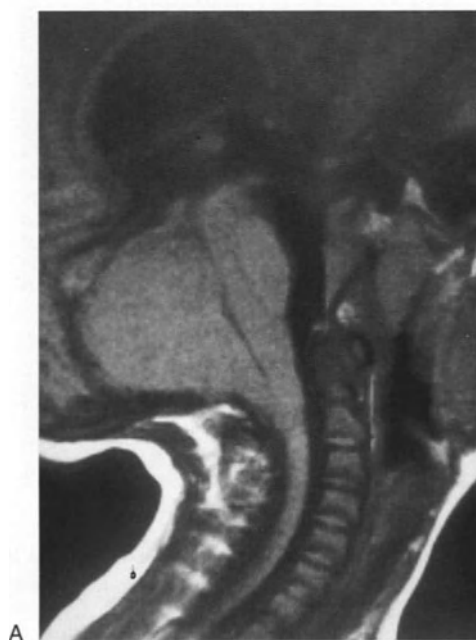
Chiari II malformation with hydrocephalus. Though the Chiari II malformation is discussed extensively in Chap. 14, "Congenital Anomalies," it is necessary to address this subject in this chapter since bi or triventricular hydrocephalus is present in slightly less than 80% of meningocele children who have a true Chiari II malformation. (A) This lateral MRI study reveals a moderate Chiari II malformation. There is tonsillar herniation, the bulb is located below the foramen magnum, the aqueduct of Sylvius is lengthened and flattened as is the IV ventricle, the culmen monticuli of the cerebellum is flattened, and the straight sinus and vein of Galen form a right angle. There is marked dilation of the III ventricle and the mammillary bodies are displaced anteriorly. (B, C) see p. 577.
